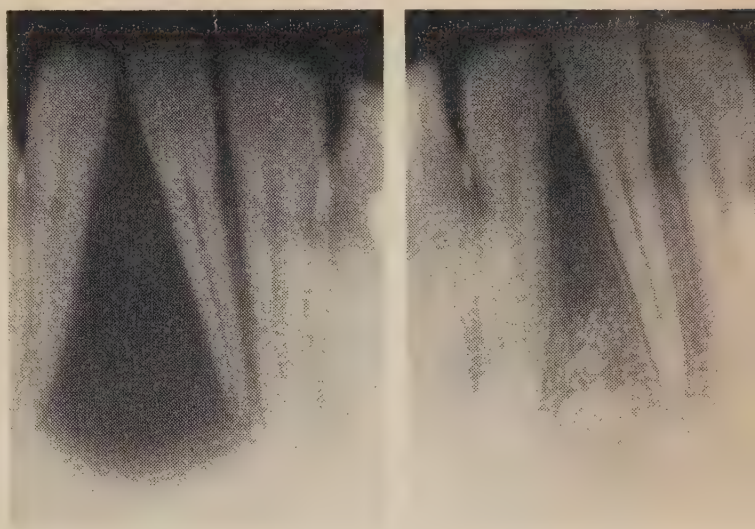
(l.) June 30, 1961: radiograph of large periapical lesion prior to placement of rubber dam drain. Both adjacent teeth are vital. (r.) December 12, 1961: radiograph taken three months after drainage was discontinued. (Marshall and Walker, D. Digest 68:573, 1962.)
